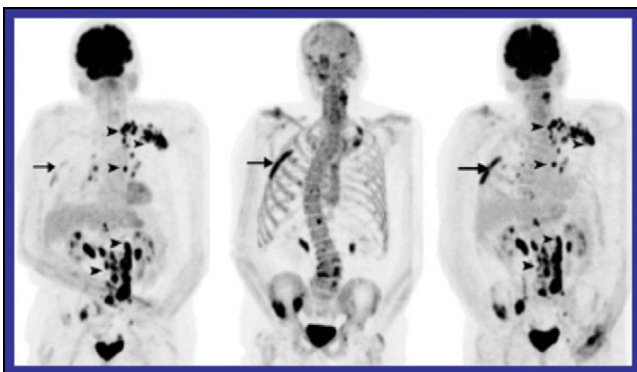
^{18}F -FDG (left), ^{18}F -fluoride (middle), and combined images (right) in a 75-y-old man with prostate cancer.
